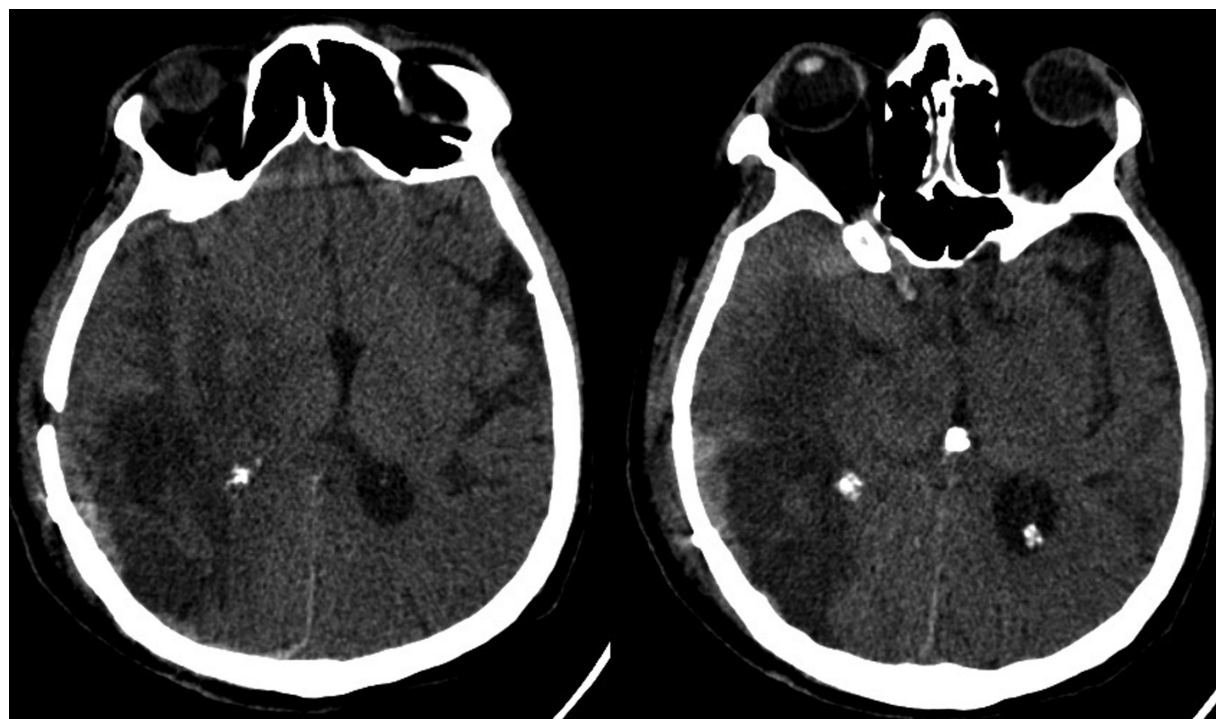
Postoperative computed tomography scan showing a tumoral lesion compromising the right parietal and temporal lobes.
